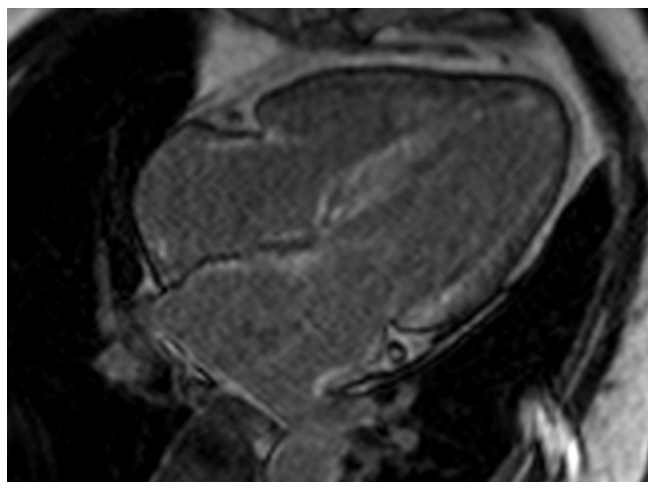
Cardiac magnetic resonance imaging showing late gadolinium enhancement of the subendocardium and mid-myocardium of the left ventricle, atrial walls and atrial septum.
